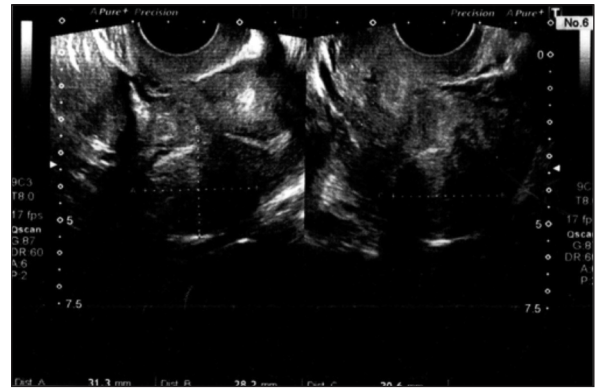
Ultrasound picture shows mixed echogenic lesion measuring 3x3 cm in uterine corpus.
